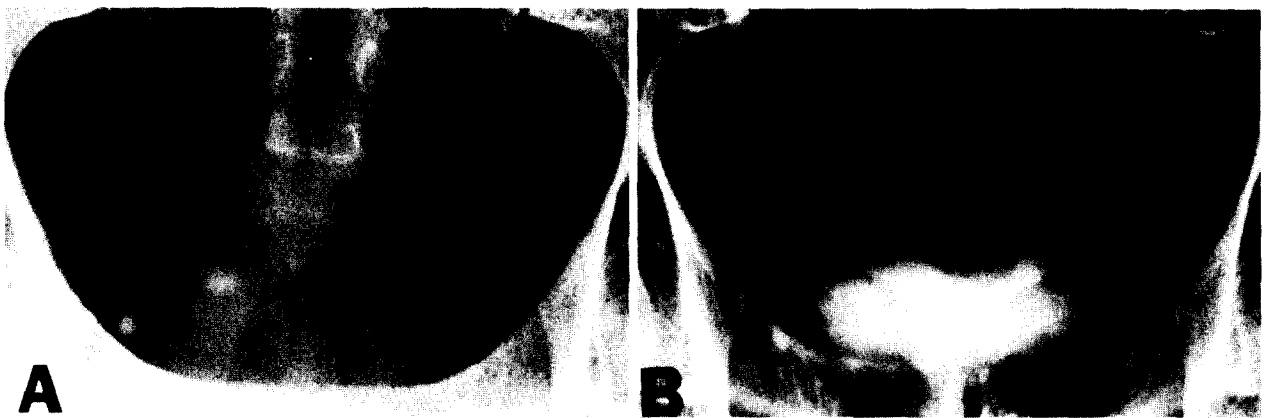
Case 3. Pseudoureterocele secondary to impacted calculus. (A) Plain radiograph of pelvis shows distal right ureteral calculus (arrow). (B) On excretory urography, calculus is obscured by contrast in pseudo-ureterocele.
